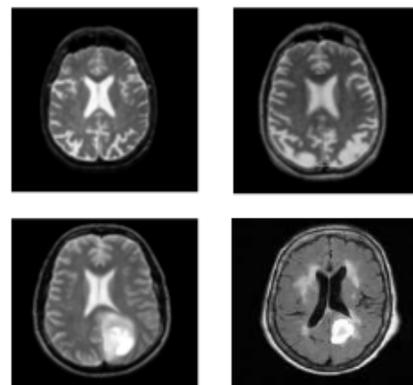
Sample MRI images of patients
